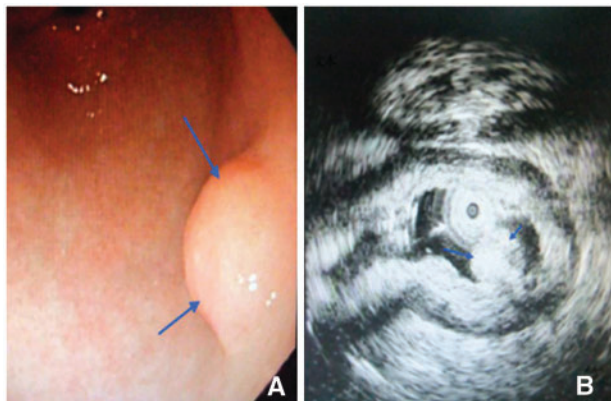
Endoscopic and endosonographic views of the plexiform angiomyxoid myofibroblastic tumor (PAMT) at the antrum of the stomach. (A) Endoscopic view of the tumor showing a 0.8×0.8 cm polyp-like mass; (B) Endosonographic image showing homogeneous hyperechoic lesion protruding into the lumen (indicated by arrows).
